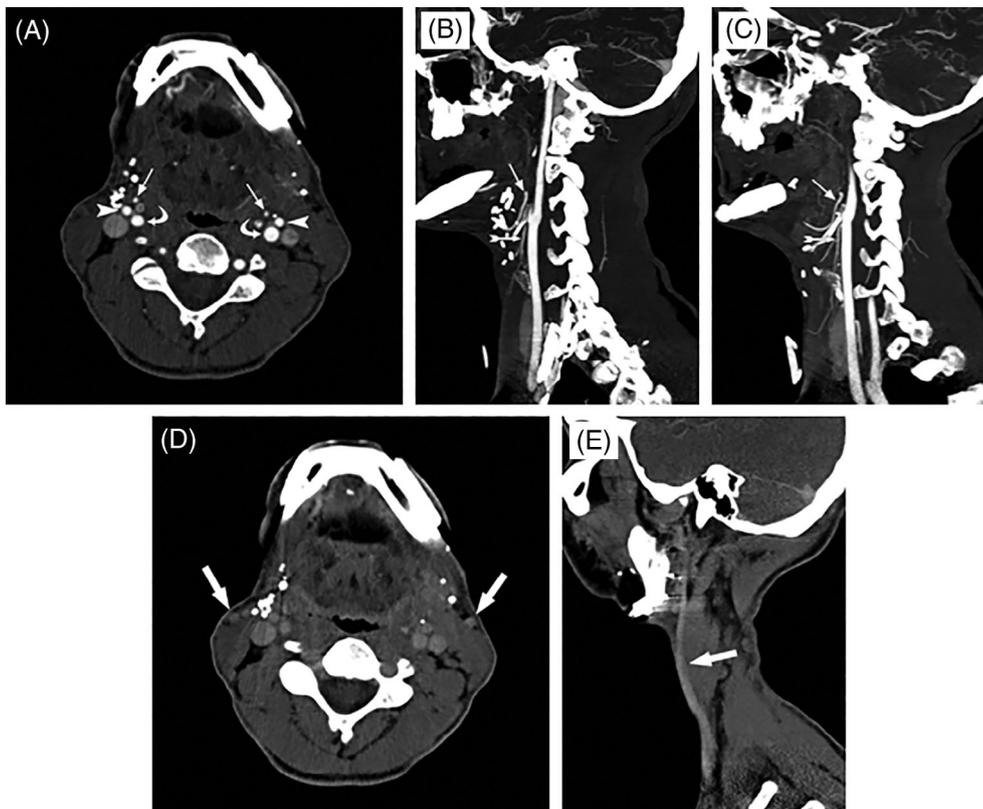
Arterial and venous phase of the dual-phase CTA for case A. Axial arterial phase image (A) and the right (B) and left (C) parasagittal thick maximum intensity projection (MIP) arterial phase images demonstrate patency of both lingual arteries (thin straight arrows in A-C) and superior thyroid arteries (hatched arrows in B and C). Axial (D) and left parasagittal (E) delayed phase images demonstrate patency with contrast opacification of the external jugular (EJ) veins (thick arrows in D and E). Opacification of the EJ veins is not evident on the arterial phase images (curved arrows in A: internal carotid arteries, arrowheads in A: external carotid arteries)
